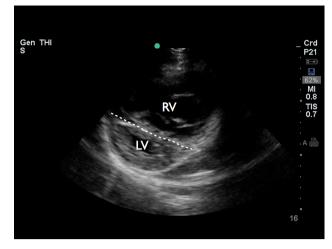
Right heart strain. This parasternal short view of the heart was obtained by placing the phased array probe to the left of sternum at approximately the fourth intercostal space with the indicator pointed toward the patient's left shoulder. The left ventricle (LV), right ventricle (RV), and interventricular septum (*dashed white line*) are all seen in this image. This parasternal short view demonstrates a dilated right ventricle and flattening of the interventricular septum, both findings indicative of right heart dysfunction. These findings may be seen in the presence of acutely elevated pulmonary pressures, as in pulmonary embolism, or chronic pulmonary hypertension. In chronic right heart dysfunction, hypertrophy of the right ventricle may be noted via a right ventricular wall thickness that exceeds 0.5 cm, the upper limit of normal for RV wall thickness. [See Supplemental Video 7]
